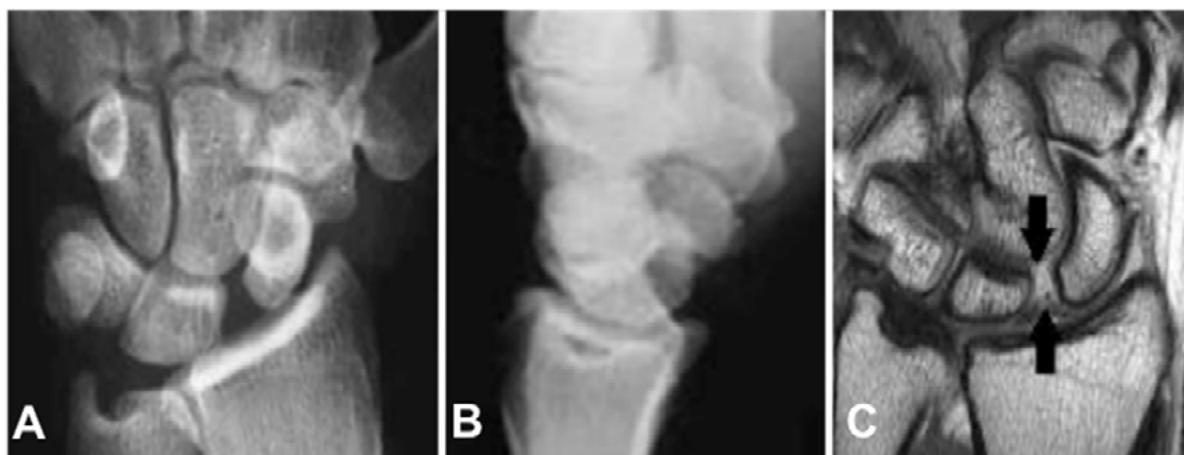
Radiographs from a 36-year-old male patient who suffered a wrist trauma with 4 months of follow-up, demonstrating an increased scapholunate interval and a DISI deformity (A and B). Magnetic resonance imaging showing a complete tear of scapholunate interosseous ligament (C).
